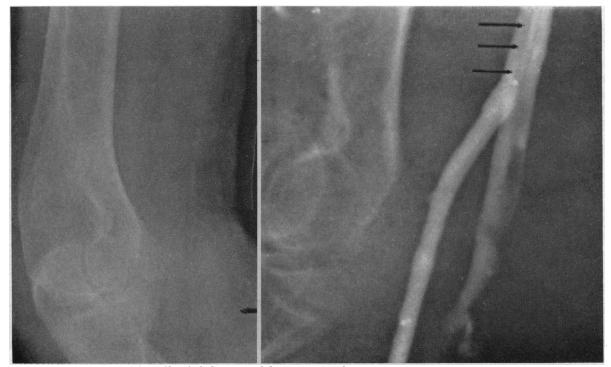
(Case 5) Plain film failed to reveal location of catheter fragment. Venogram showed it within an anticubital vein.
